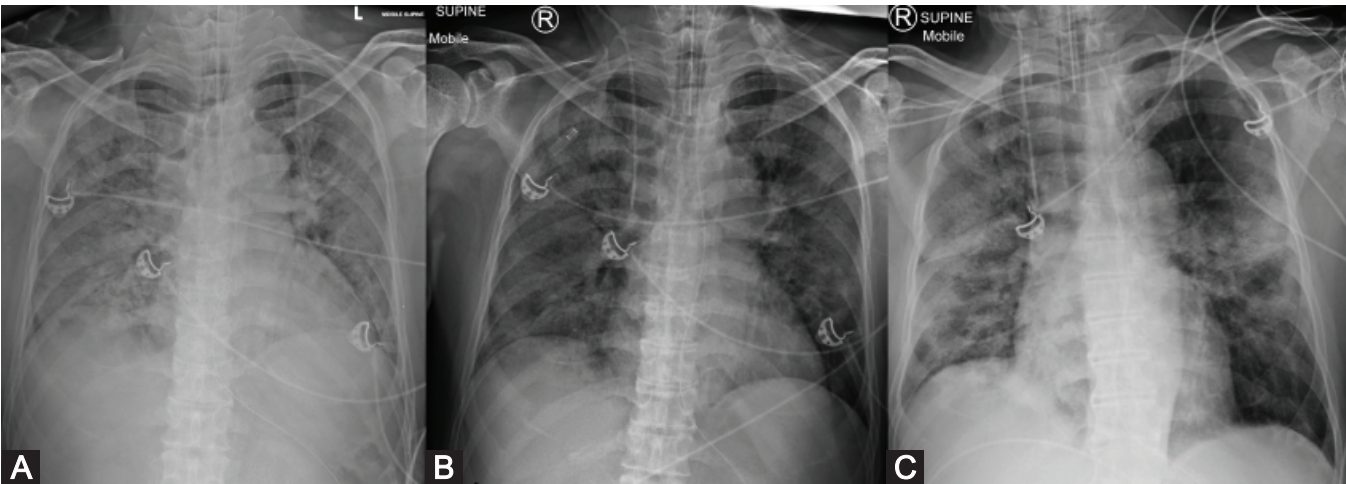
A: Chest radiograph after endotracheal intubation. B: On day 4, chest radiograph showed mild improvement in extensive airspace opacification. C: On day 11, chest radiograph showed interval development of patchy consolidation in right lung and focal consolidation in left mid-zone. A nasogastric tube (A, B and C) and right internal jugular venous catheter (B and C) were inserted.
